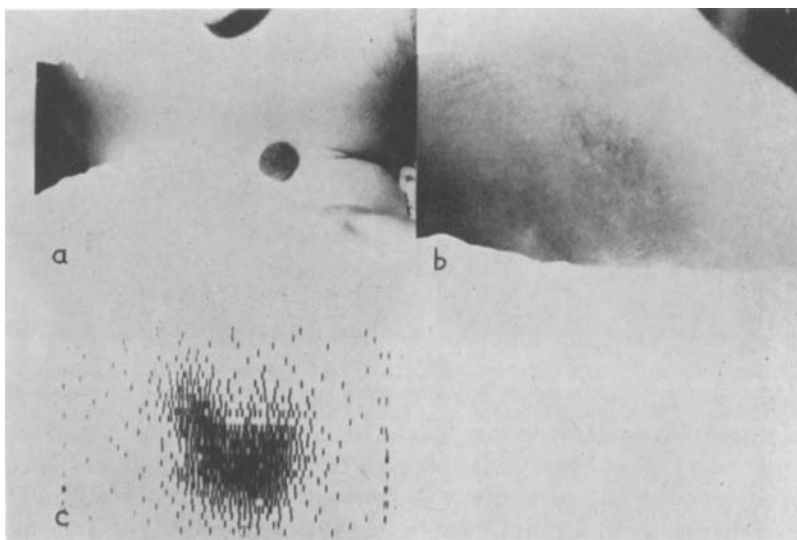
a) Appearances of haemangioma before radiotherapy. b) State of skin at control-examination with (c) scintigram and radioiodine tracer tests; dose administered $7.5 \mu\text{Ci}$, thyroid uptake 2 hrs 23 %, thyroid uptake 24 hrs 42 %, urine excretion 0—24 hrs 33 %.
